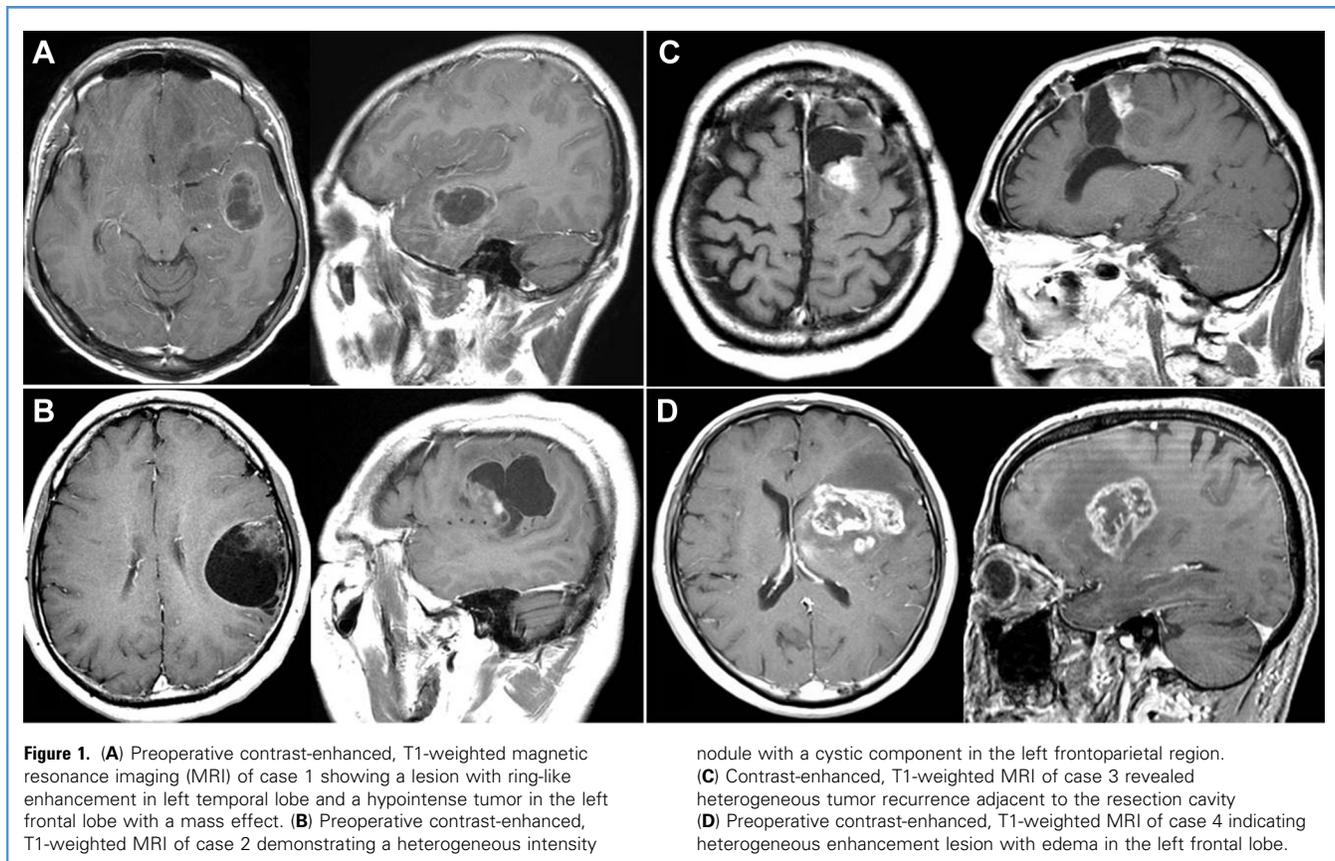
(A) Preoperative contrast-enhanced, T1-weighted magnetic resonance imaging (MRI) of case 1 showing a lesion with ring-like enhancement in left temporal lobe and a hypointense tumor in the left frontal lobe with a mass effect. (B) Preoperative contrast-enhanced, T1-weighted MRI of case 2 demonstrating a heterogeneous intensity
